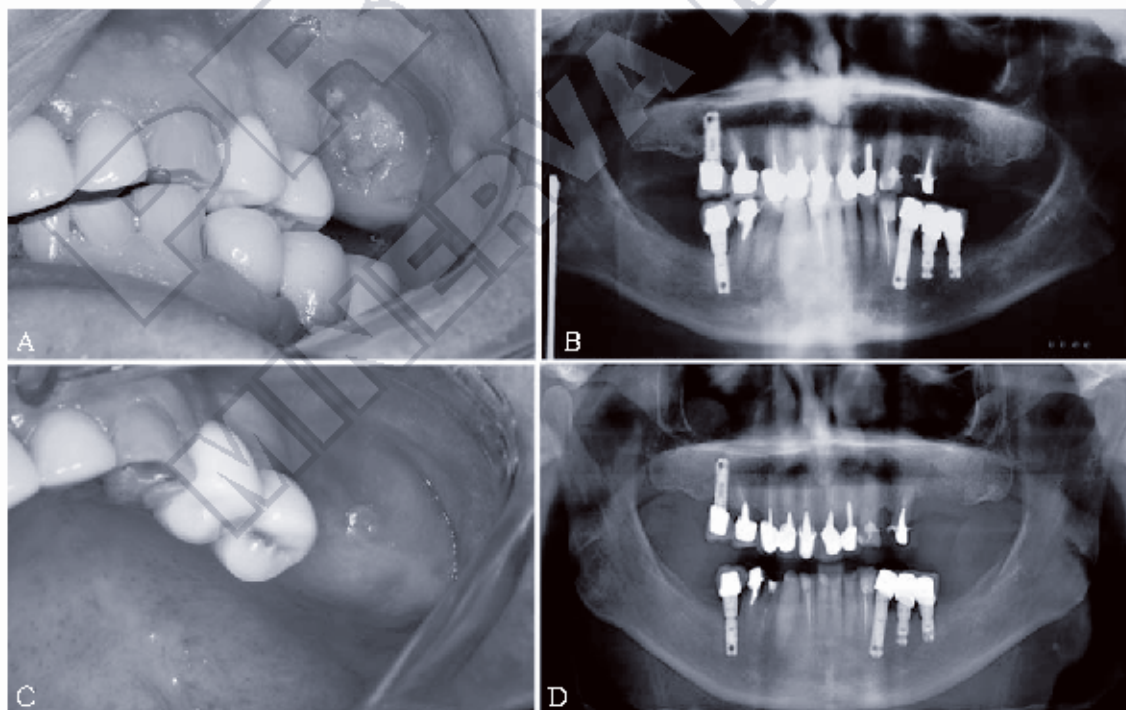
Case 1 (A) Bone exposure in the maxilla first left molar region surrounded by a friable erythematous mucosa (B); panoramic radiograph image showing a slight bone defect; C) Clinical aspect after three-year of treatment shows normal mucosa; D) Panoramic radiograph image showing bone defect but any bone sequestrum.
